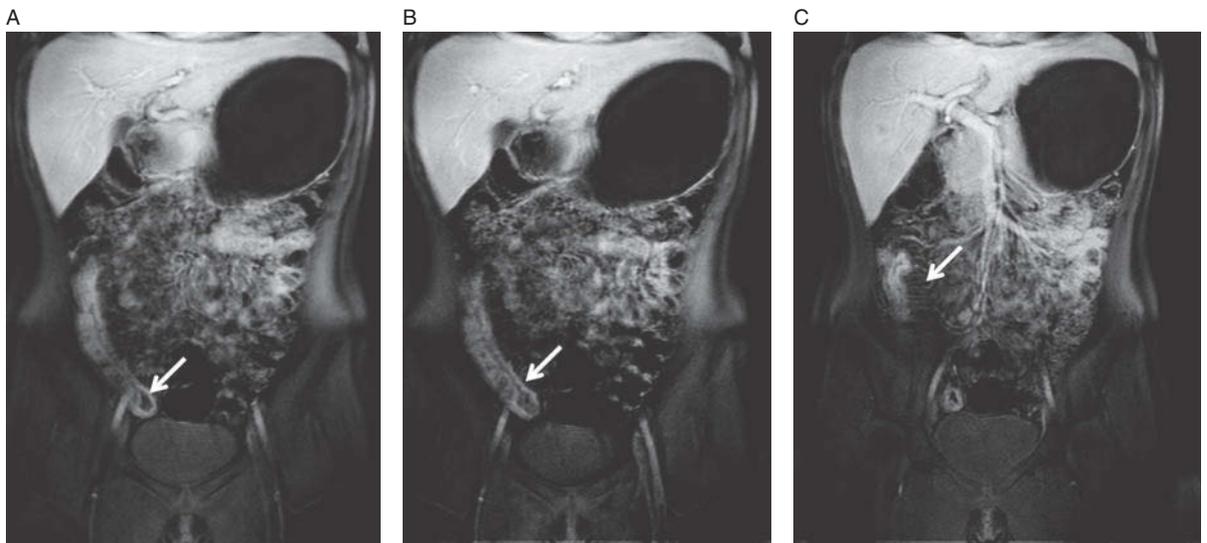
Active terminal ileitis. Contiguous coronal T1-weighted, fat-saturated images obtained 35 seconds following injection. Note the abnormal mucosal enhancement (A, B) as well as the engorgement of the mesenteric vasculature (the "comb" sign) (C).
